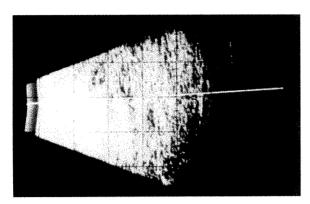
(Whitacre). An almost complete gas-fill is present after vitrectomy. When the patient's head was erect and the ultrasound probe was held in line with the visual axis, only the confluent reverberations of a gas-tissue interface were seen.
